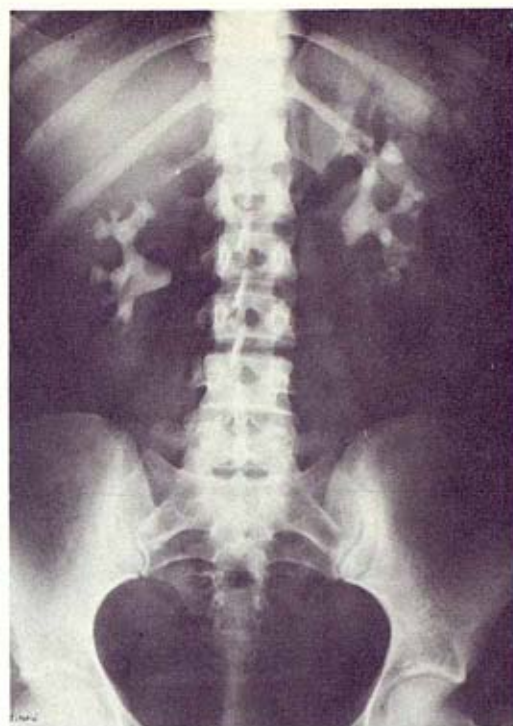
(Ob.I) Simple X-ray. Bilateral staghorn.
